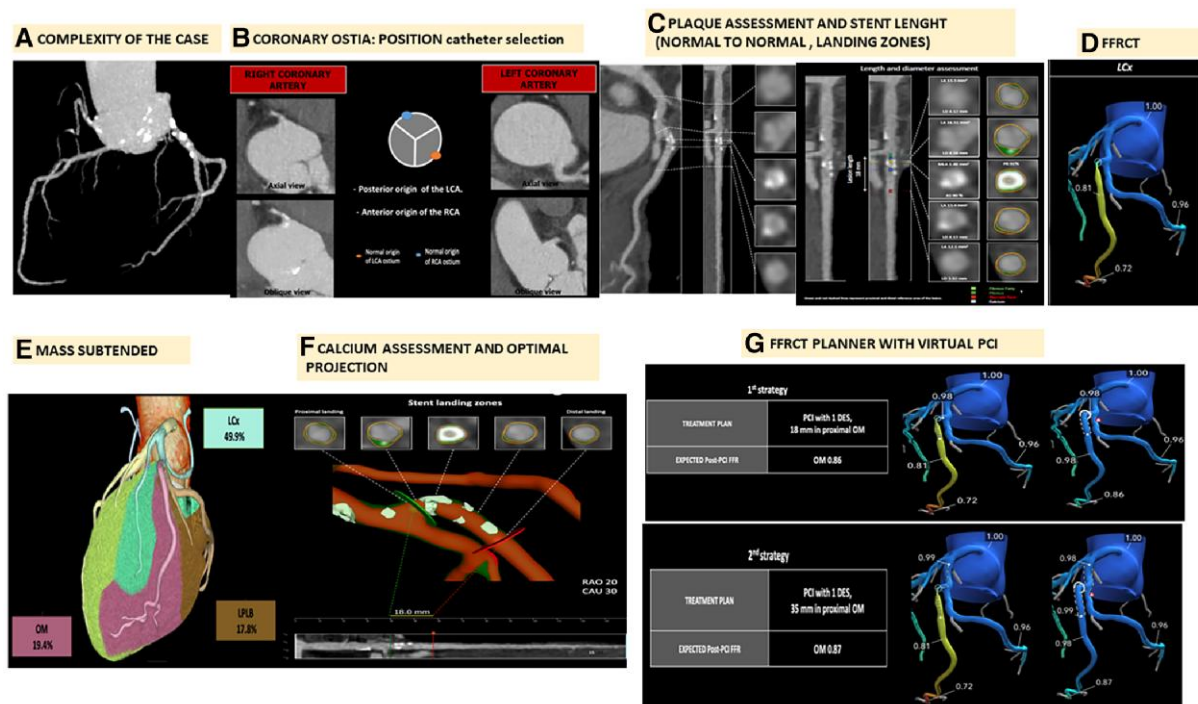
Example of a planning of percutaneous coronary intervention procedure by coronary computed tomography angiography. A case of 78-year-old male with angina symptoms and a severe stenosis on marginal branch. The different phases of planning percutaneous coronary intervention by coronary computed tomography angiography are shown: (A) the maximal intensity projection images anticipate the complexity of case and calcium burden; (B) the axial images showed the coronary ostia position (in this case anterior for right coronary artery and posterior for left main artery) suggesting the catheter to use during ICA; (C) plaque assessment with evaluation of the lesion length (stent length) considering stent landing zone in normal vessels; (D) functional evaluation by fractional flow reserve from coronary computed tomography angiography images showed an fractional flow reserve of 0.72 on marginal and a delta-fractional flow reserve of 0.27; (E) the mass subtended by the marginal branch is big 19.4%; (F) calcium assessment showed circumferential deposition but short in length suggesting a preparation of the lesion with a NC balloon 1:1; moreover, optimal projection for the lesion assessment has been shown before ICA; (G) fractional flow reserve from coronary computed tomography angiography images planner and virtual percutaneous coronary intervention shows two possible strategies: one with a short stent of 18 mm with a fractional flow reserve from coronary computed tomography angiography images post-percutaneous coronary intervention expected of 0.86 and a longer stent of 35 mm with a fractional flow reserve from coronary computed tomography angiography images post-percutaneous coronary intervention of 0.87. CCTA, coronary computed tomography angiography; ICA, invasive coronary angiography; PCI, percutaneous coronary intervention; LM, left main artery; MIP, maximum intensity projection; RCA, right coronary artery.
